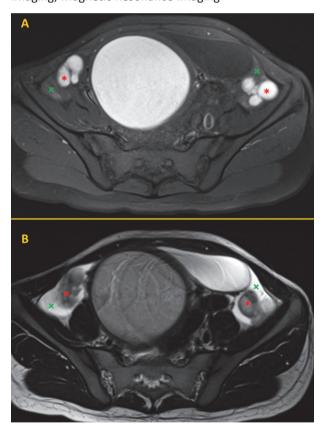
Axial T1-weighted (A) and T2-weighted (B) magnetic resonance images showing the extremely large and dilated uterus filled with a hyperintense content as well as the dilated Fallopian tubes (red asterisks) and intraperitoneal free fluid (green crosses), compatible with a massive hematometra associated with bilateral hematosalpinx.
